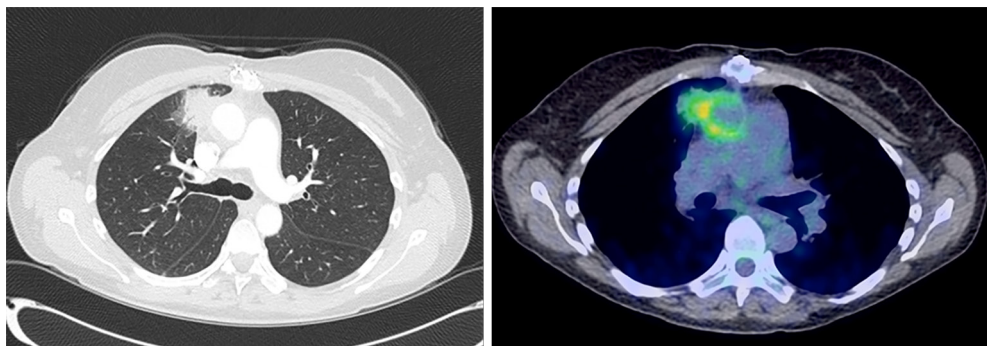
Chronic Q fever lung pseudotumor. One patient with chronic Q fever was noted to have a right upper lobe mass-like consolidation, which exhibited lymphoplasmacytic infiltration in the background of fibrosis on CT-guided needle biopsy. Subsequent, PET scan showed increased FDG accumulation in the soft tissue thickening along the ascending aorta and contiguous medial right upper lobe consolidation and manubrial erosion.
